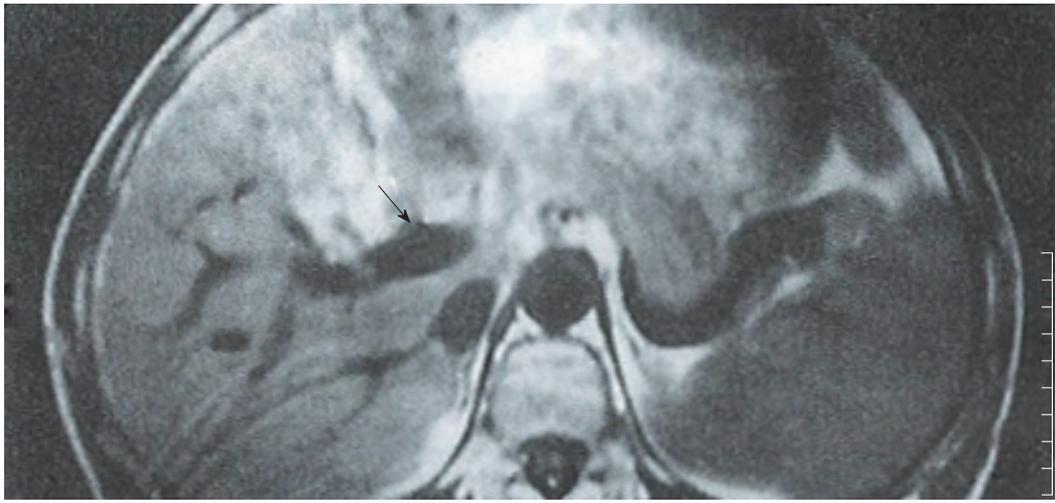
Patient with HCC. T1 weighed (500/15) MR images of the upper abdomen showed the portal tumor thrombus as a clot of iso-signal intensity (arrow).
